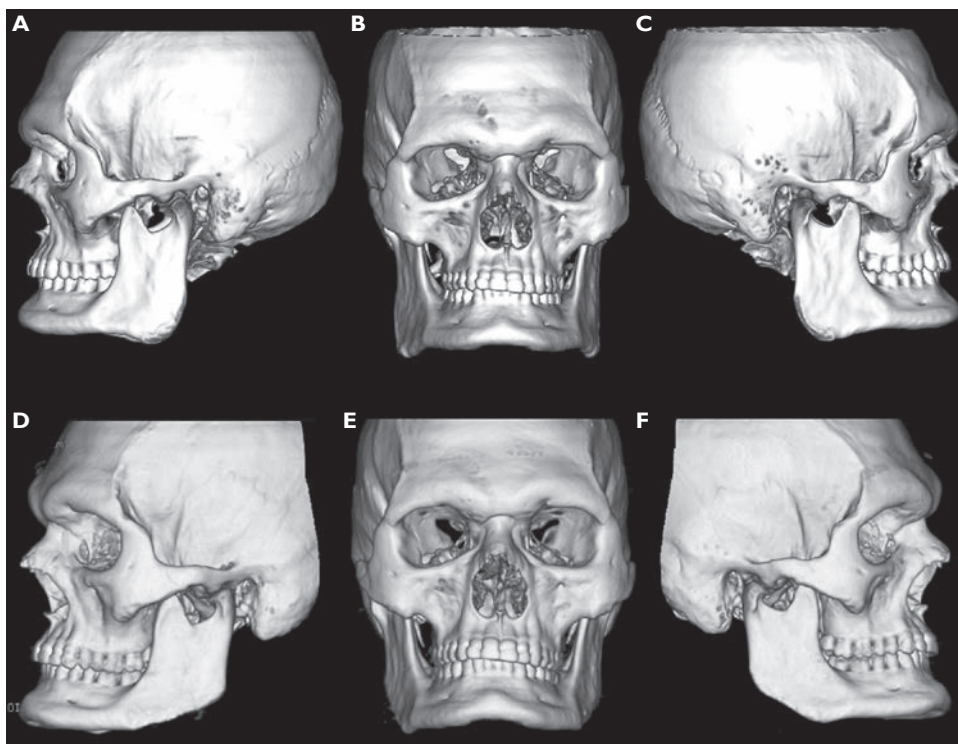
A) Initial computed tomography in 3D reconstruction of the patient in $\frac{3}{4}$ left view; B) initial computed tomography in 3D reconstruction of the patient in frontal view; C) initial computed tomography in 3D reconstruction of the patient in $\frac{3}{4}$ right view; D) postoperative computed tomography in 3D reconstruction of the patient in $\frac{3}{4}$ left view; E) postoperative computed tomography in 3D reconstruction of the patient in frontal view; F) postoperative computed tomography in 3D reconstruction of the patient in $\frac{3}{4}$ right view.
